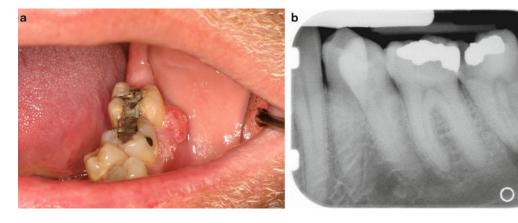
Left mandibular gingival swelling (a) associated with abscessed second molar with a fractured amalgam restoration with underlying recurrent caries. (b) Periapical
